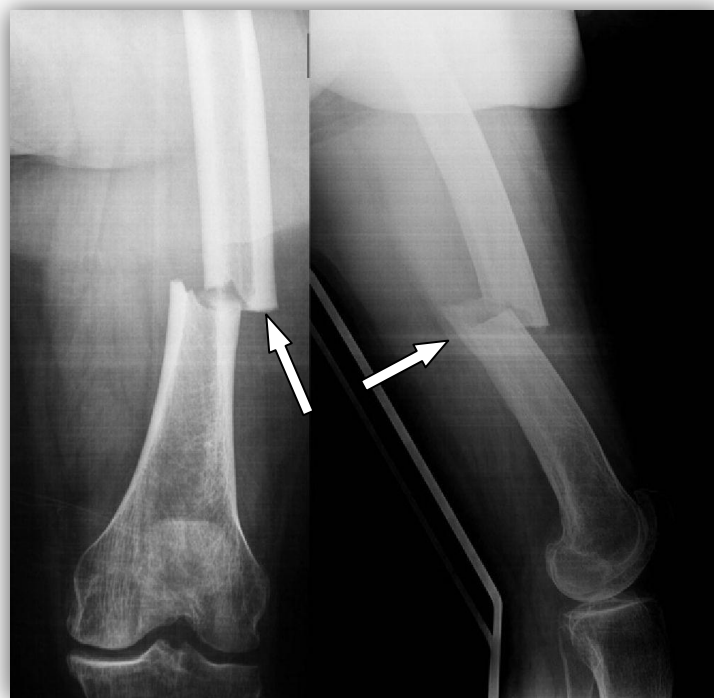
Radiographic picture of an atypical femur fracture. The arrows show the transversal fracture and thickened cortices with a unicortical beaking [90]. (Permission to use images granted by Ana Méndez.)
